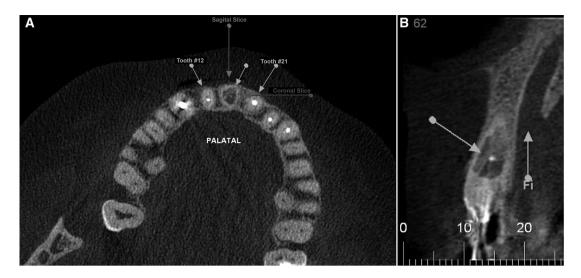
Initial CBCT images confirming the extension of the internal root resorption lesion on the right maxillary central incisor: (A) coronal and (B) transaxial sections.
